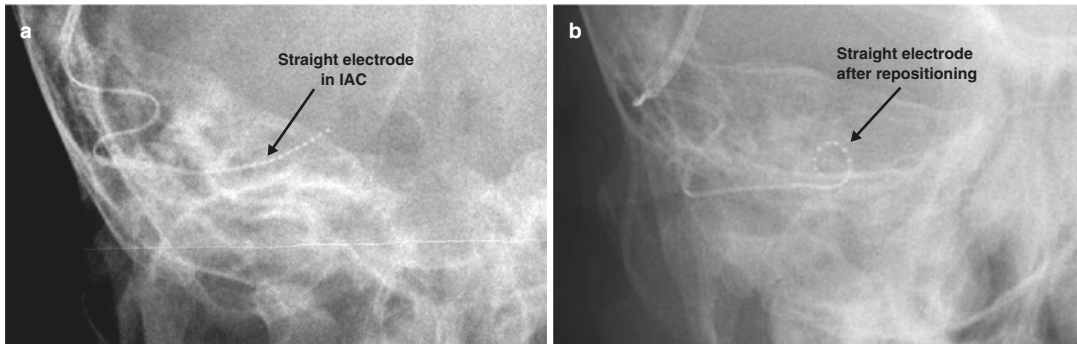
Case 25.2 (a) Intraoperative X-ray taken showing a straight electrode: electrode migration into IAC, (b) satisfactory electrode placement around cochlea after repositioning
